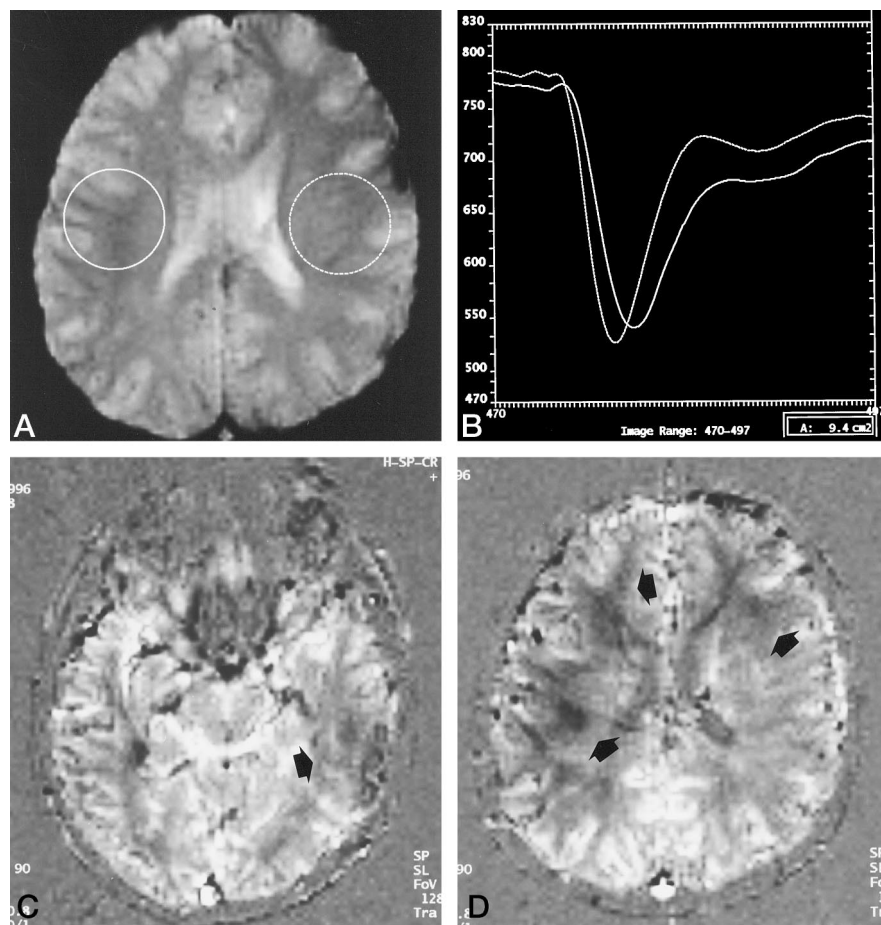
Case 11: 14-year-old boy with moyamoya disease affecting both sides almost equally. The patient had several lacunar infarctions in the bilateral frontal lobes and the right parietal lobe on conventional MR images.
